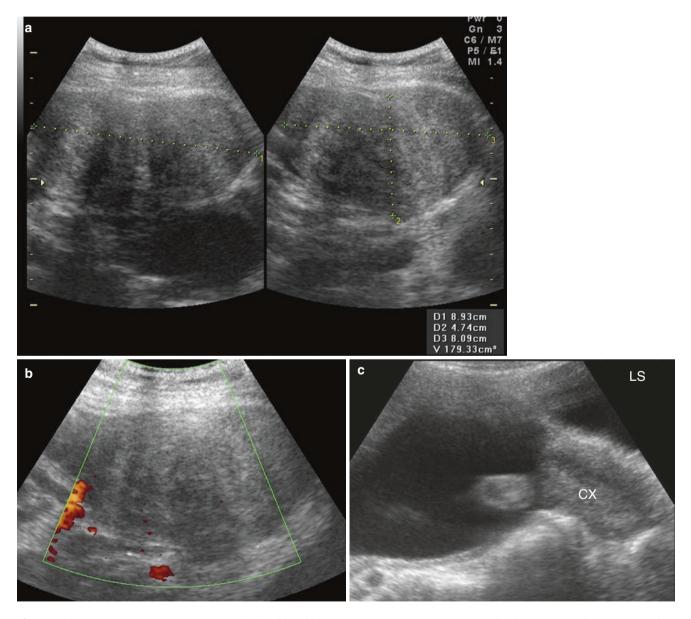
Suspected case of red degeneration of a fibroid. A 23-week-pregnant lady, known to have a fibroid, presented with acute abdominal pain. On ultrasound examination, the fibroid was very tender. (a) Fibroid on measurement was found to have increased in size suddenly. (b) No flow was seen on power Doppler in the fibroid. (c) Cervix was found to be of normal length, and there was no evidence of placental abruption
